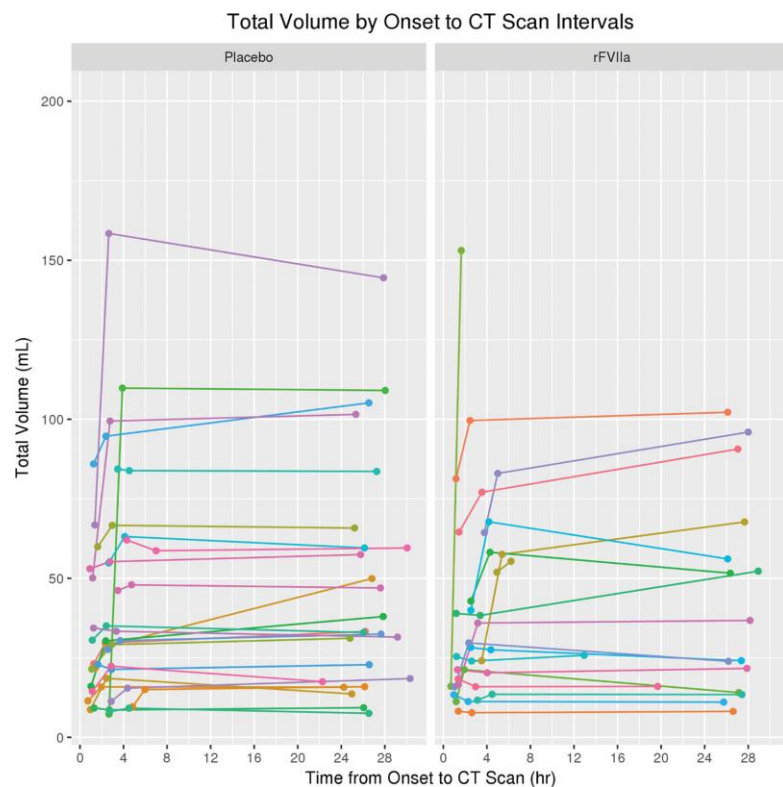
Evolution of total hematoma volume measured with 3 computed tomography (CT) scans over the 24 h in the placebo and treatment arms. In most patients, the hematoma expansion occurred between the baseline and early post-dose CT scan. rFVIIa indicates recombinant activated factor VIIa.
